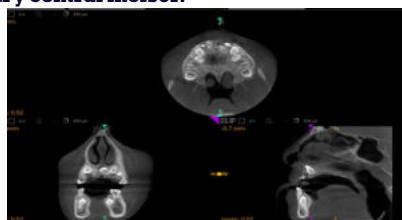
Cone-beam computed tomography (CBCT) for
